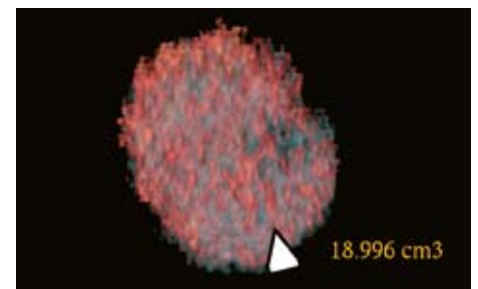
e, f and g: At contrast-enhanced CT, the lesion was as much enhanced as the normal cortex. However, the cranio-caudal length was underestimated and was over 4 cm. The true tumor volume was almost reaching 19 cm<sup>3</sup>.
